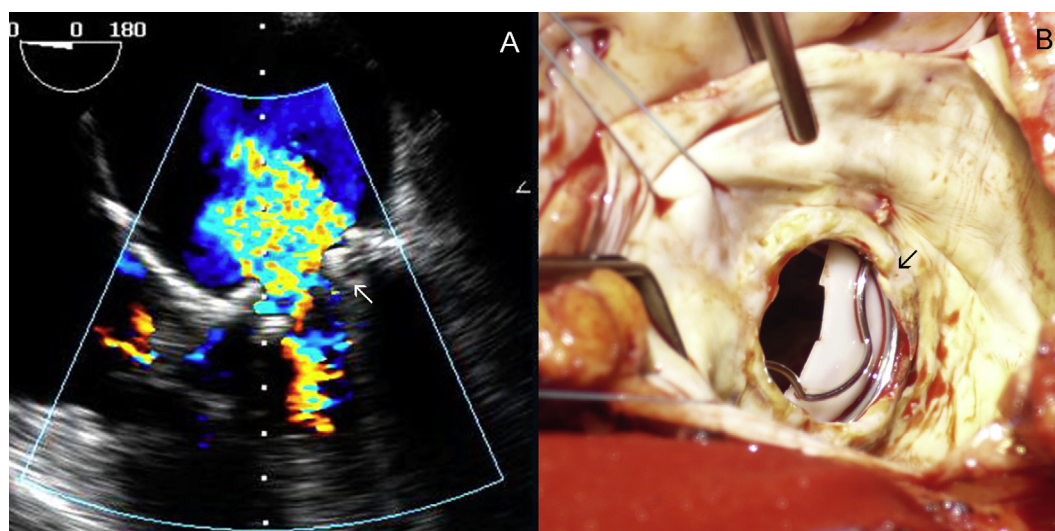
(A) Transoesophageal echocardiography showing mitral valve prosthesis dysfunction causing massive mitral valve regurgitation; (B) Intraoperative image of complete fracture of Björk-Shiley Delrin prosthesis.
